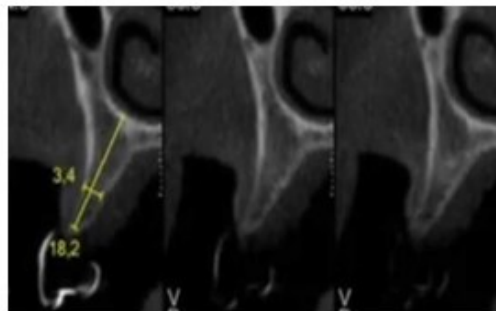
Presurgical radiograph (CT-scan)
